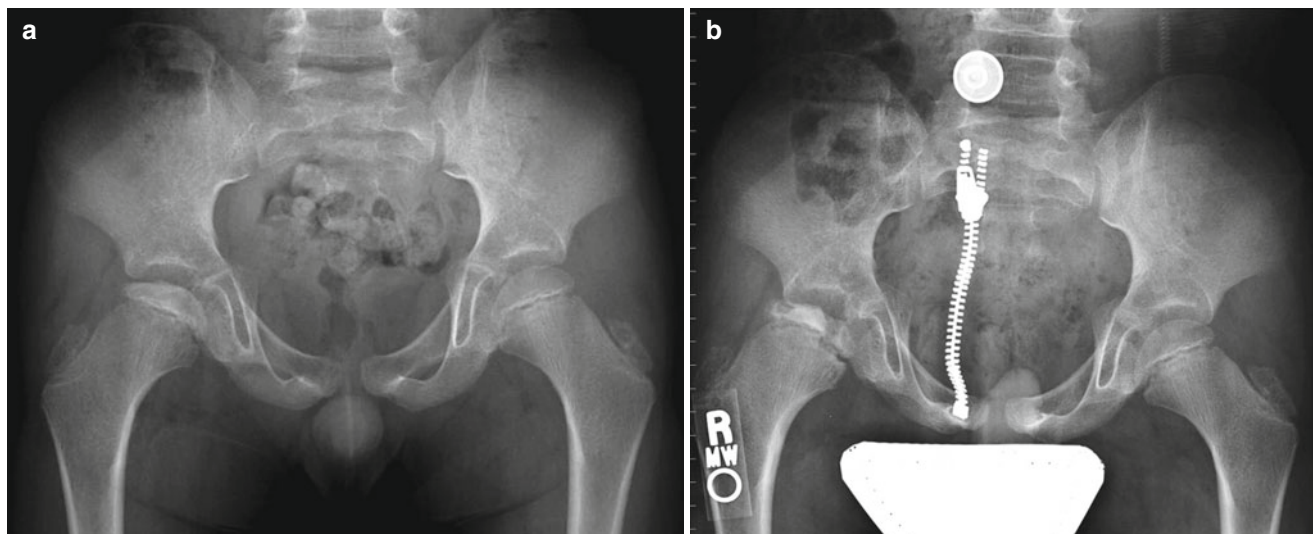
Eight-year-old boy with right hip pain for 5 months. (a) AP pelvis radiograph showing a smaller epiphysis due to growth arrest of the epiphysis. Note the increased radiodensity of the epiphysis. The femoral head is in the initial stage of LCPD. (b) AP pelvis
